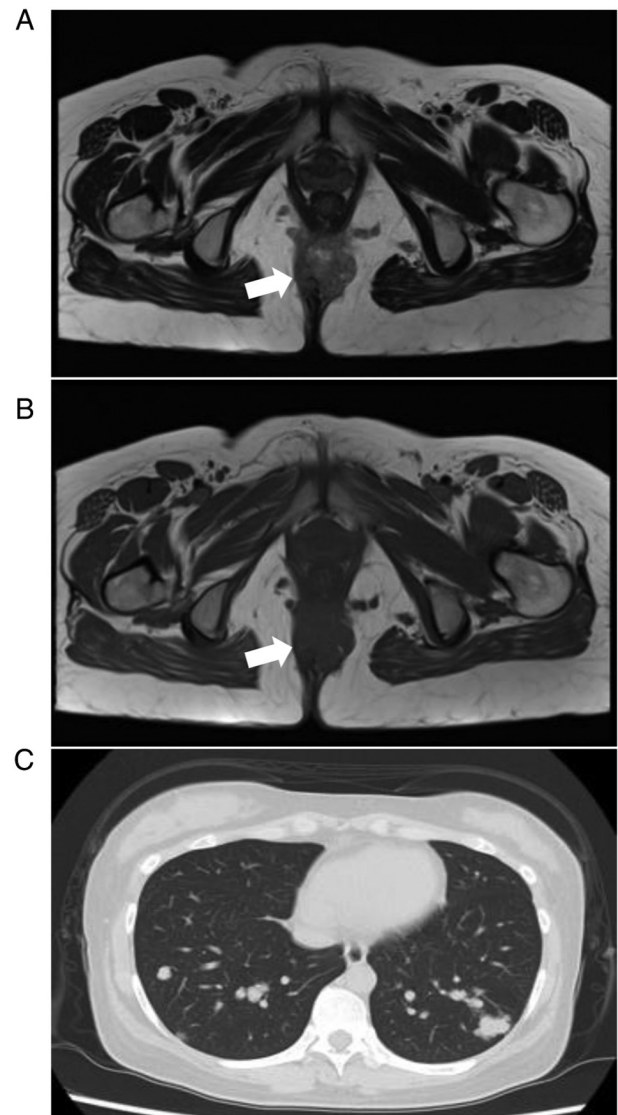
MRI images. (A) T2 weighted image; (B) T1 weighted image. A 60-mm lobulated solid mass was located in the subcutaneous adipose tissue of the buttocks (white arrows). (C) Chest CT revealed multiple metastases in both lungs.
